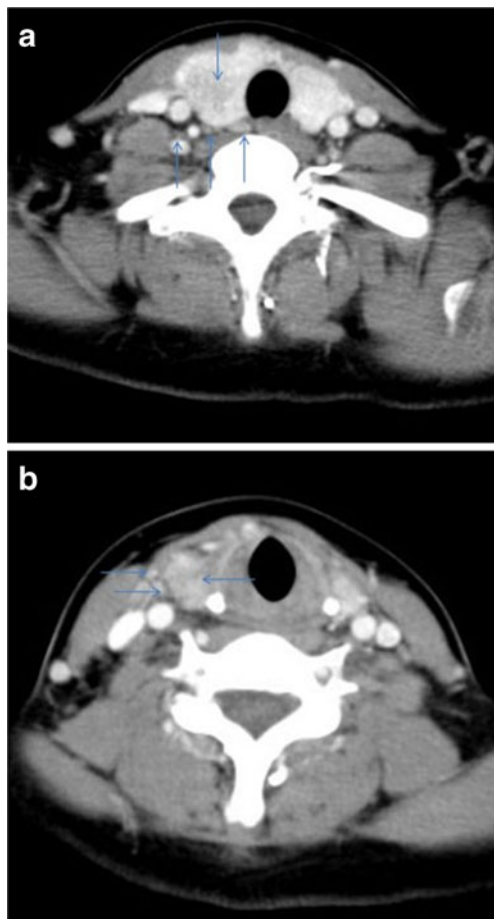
a In a 21-year-old female patient, right PTC with multi-enlarged lymph nodes was shown on CT scan preoperatively. *Down arrow*: thyroid carcinoma, *up arrow*: enlarged lymph node. b In a 21-year-old female patient, right PTC with enlarged lymph nodes in lateral neck was shown on CT scan preoperatively. *Right arrow*: enlarged lymph node, *left arrow*: thyroid carcinoma
